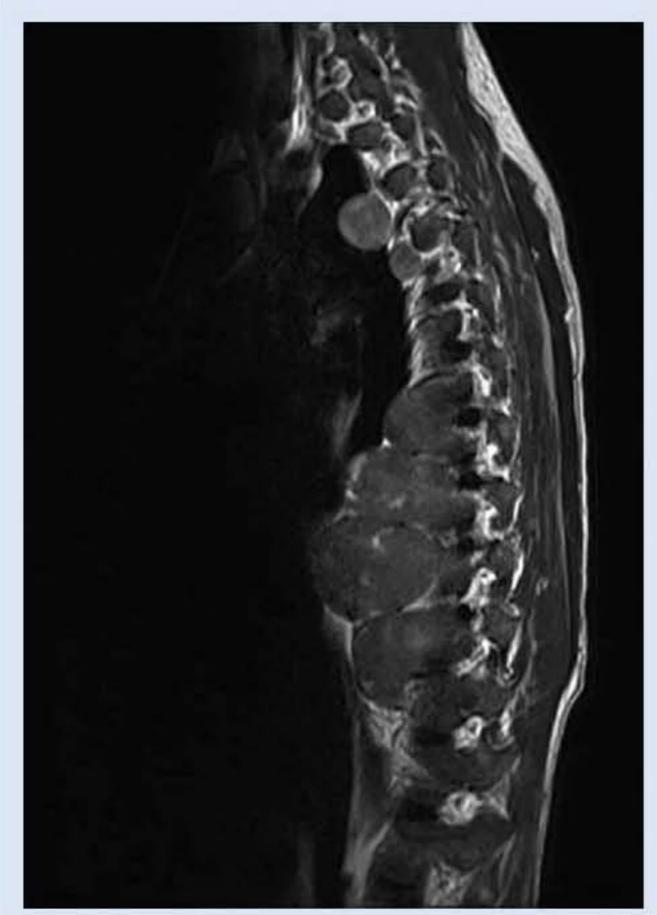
Para-sagittal T1-weighted sequence demonstrates multiple lobulated masses extending from the thoracic vertebrae which are iso-intense to the vertebral bodies. The masses extend laterally and anteriorly into the posterior mediastinum.
